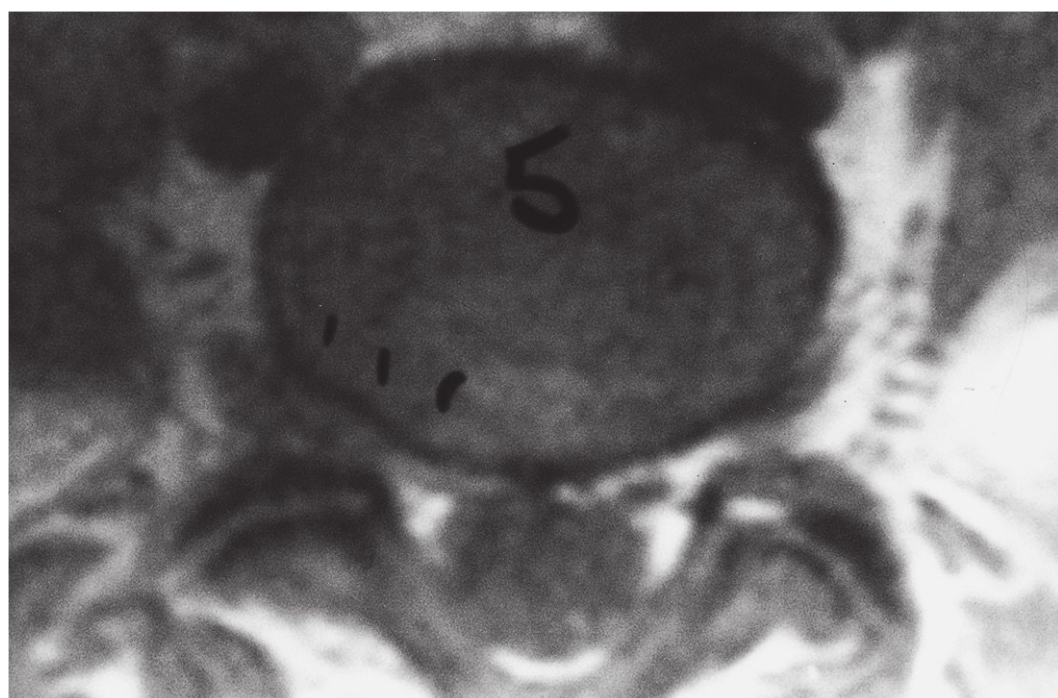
An axial magnetic resonance imaging scan demonstrating a large far lateral disk herniation at L5–S1 causing impingement on the right L5 nerve root.
